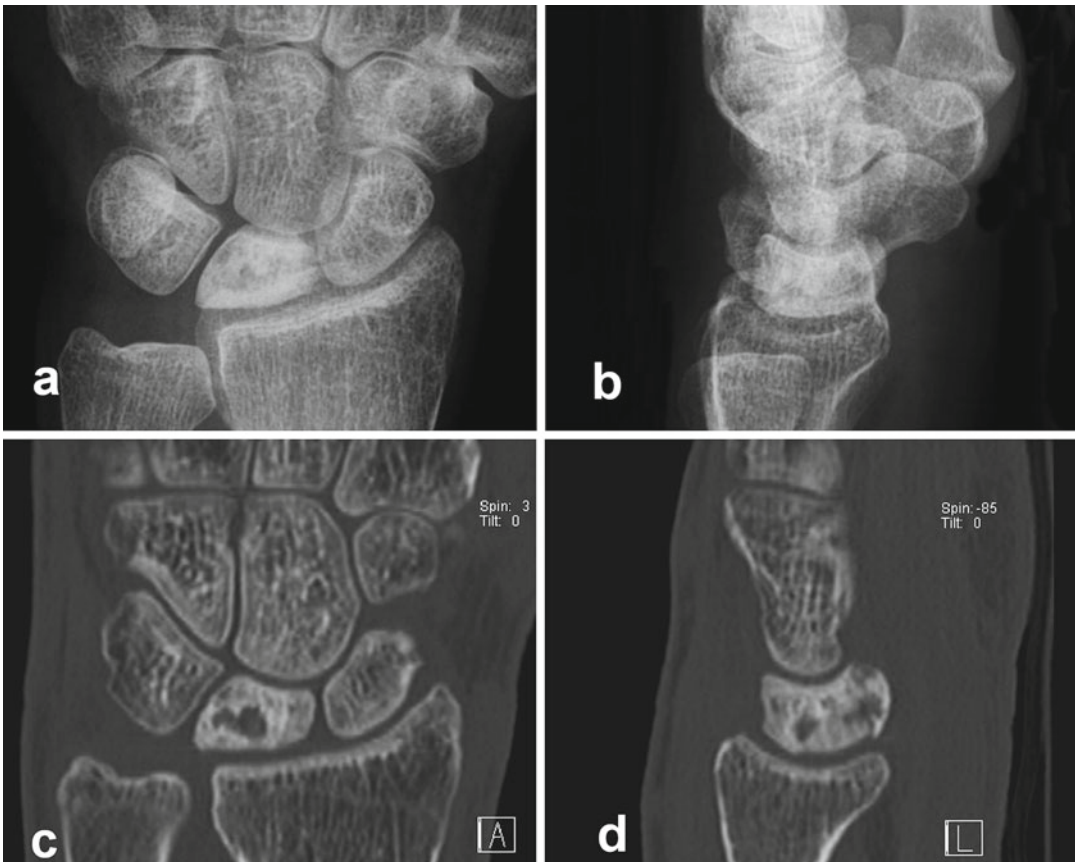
Plain radiology and CT scan of a 49-year-old female with wrist pain for 3 months. (a, b) Dorsopalmar and lateral radiographs demonstrate osteosclerosis and flattening of the proximal lunate. This would be defined as a Lichtman stage II. (c, d) Coronal and sagittal MPR
